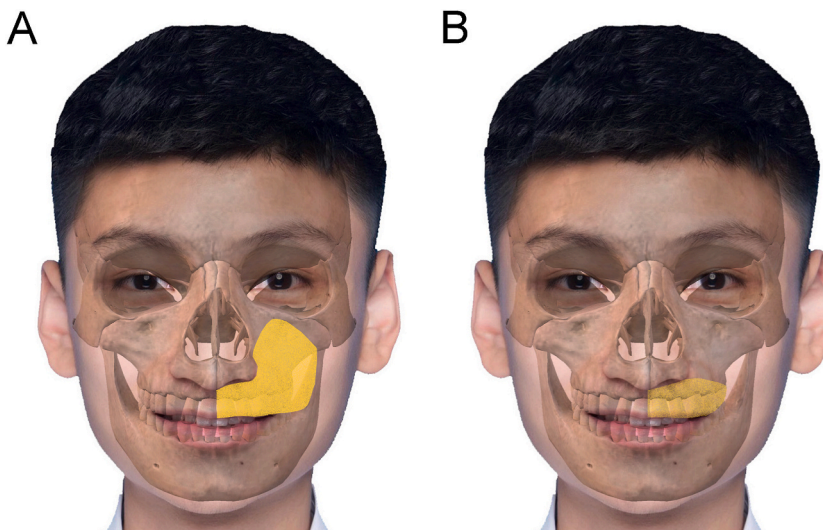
The extra- and intra-oral flap islands were designed by the combination of 3dMD and CBCT digitally. (1A) Yellow area shows the size and shape of the extra-oral flap. (1B) Yellow area shows the size and shape of the intra-oral flap.
